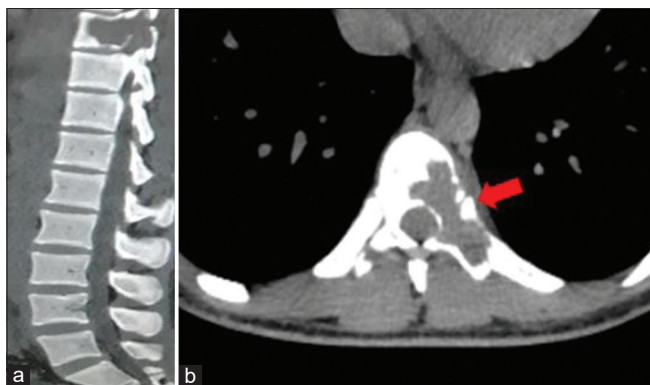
Computed tomography of the spine. (a) Sagittal section showing typical expansile, osteolytic bony destruction of T9 vertebra with posterior epidural extension and cord compression. (b) Axial section showing lytic lesion with egg shell layer (marked with arrow) of the T9 body involving the left pedicle, lamina, and spinous process.
